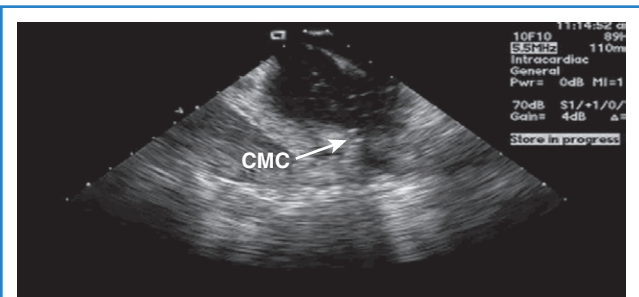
Intracardiac echocardiography image of the left atrium. An ablation catheter is delivering radiofrequency ablation energy near the circular mapping catheter (CMC). Formation of microbubbles is demonstrated.
